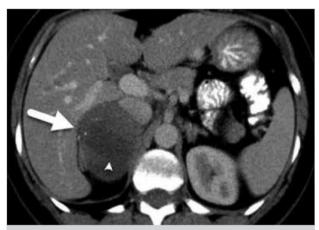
Heterogeneous mass (white arrow) having solid and cystic components (top of arrow) in contrast enhanced axial CT
